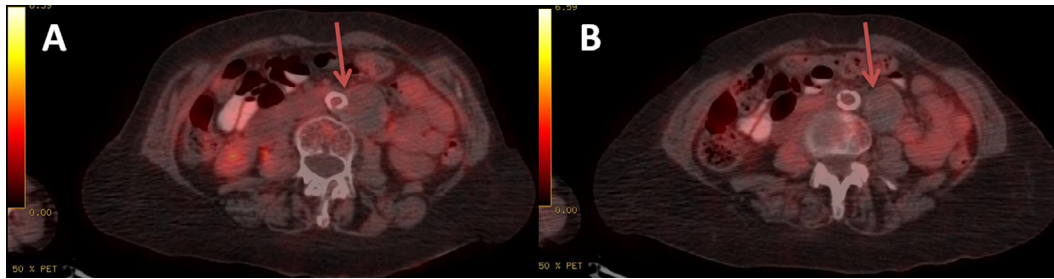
PET-CT revealed no sign of either infected arterial wall (3 - A, arrow) or mycotic abdominal aortic aneurysm (3 - B, arrow).
